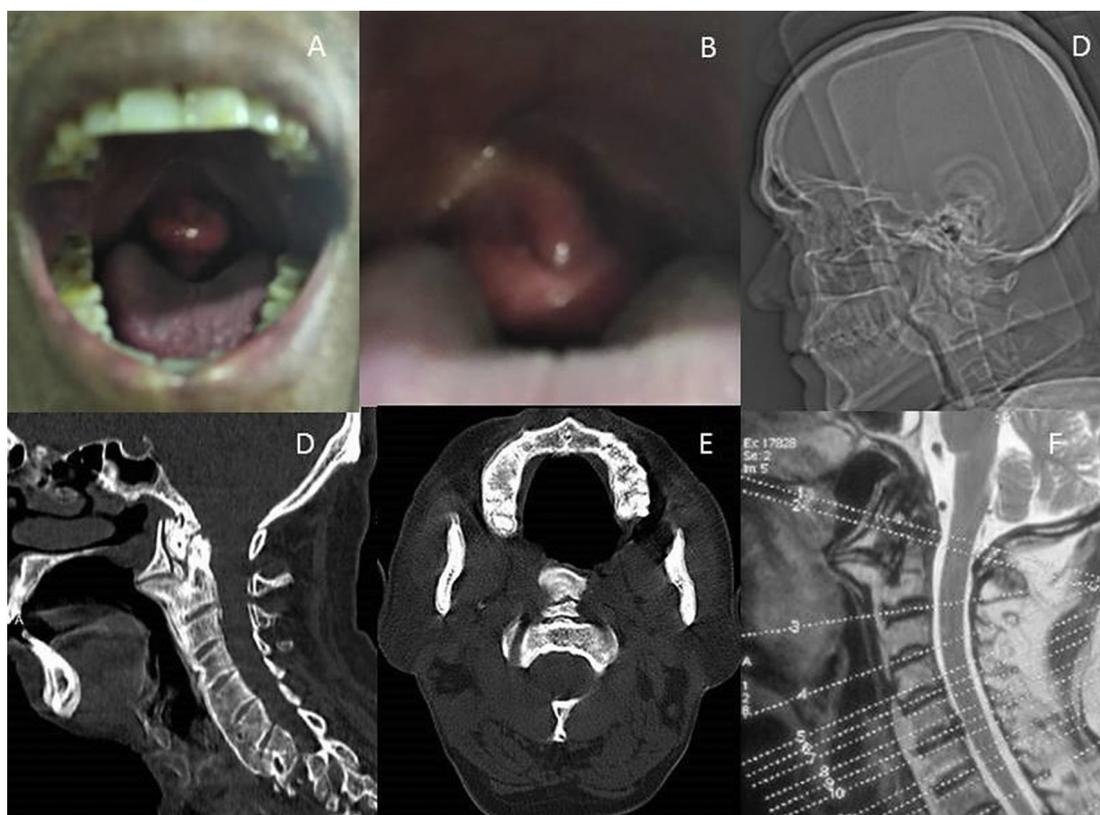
A) Clinical photograph of the patient showing a large protuberance in the retropharyngeal wall. B) Magnified view of the same. C) Lateral skull topograph, D) Sagittal CT, E) Axial CT, F) Sagittal MRI images of the patient showing marked anterior beak-like osteophyte at C1-C2 level, with marked ossification of anterior longitudinal ligament and relative preservation of intervertebral disc spaces.
